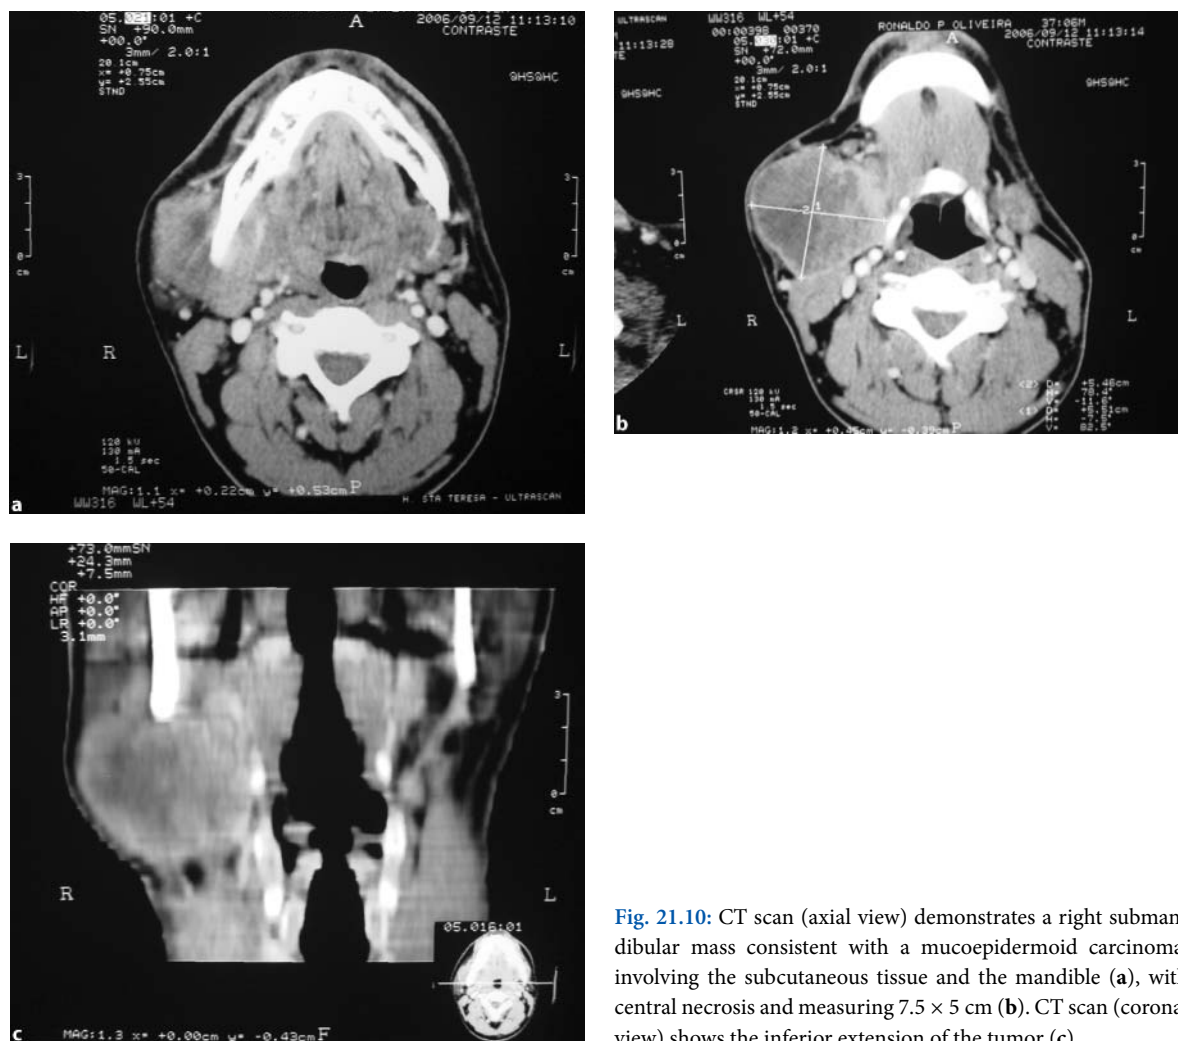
CT scan (axial view) demonstrates a right submandibular mass consistent with a mucoepidermoid carcinoma, involving the subcutaneous tissue and the mandible (a), with central necrosis and measuring 7.5 × 5 cm (b). CT scan (coronal view) shows the inferior extension of the tumor (c)
